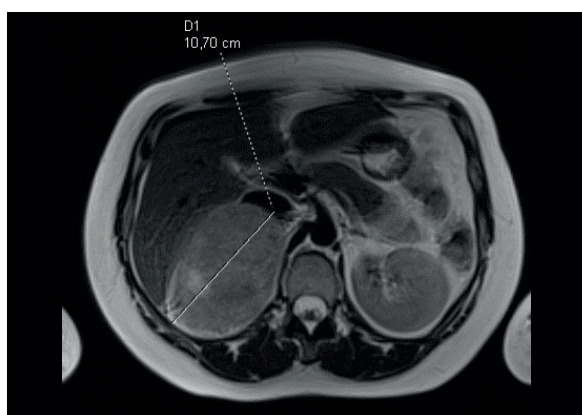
MRI, T₂-weighted image showing 11 cm oval, well-circumscribed mass with high, heterogeneous signal, higher than the adjacent liver
